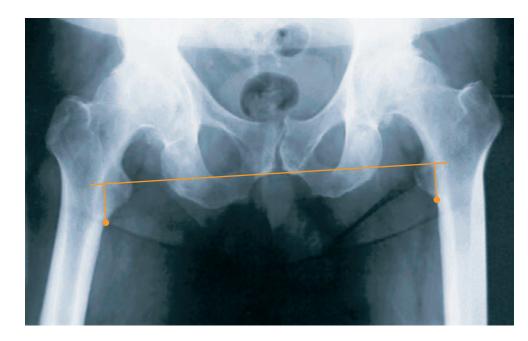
Anteroposterior radiograph demonstrating leg length inequality
